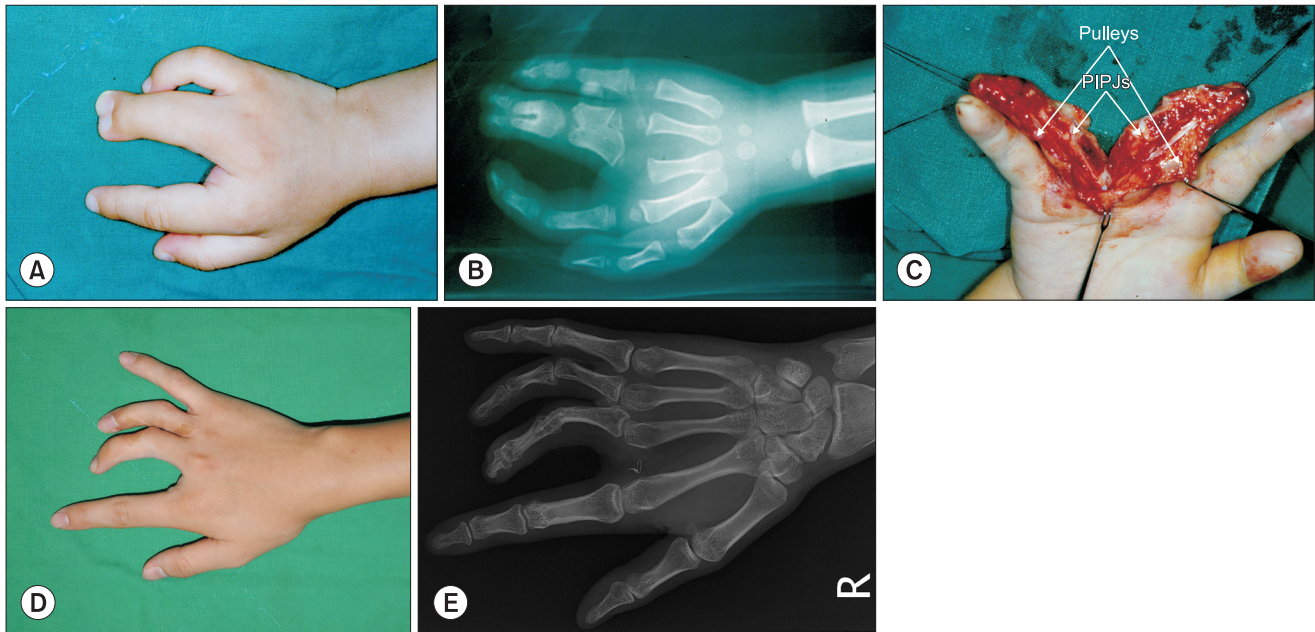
A complicated syndactyly of the right 3rd web of a case 19. (A) Preoperative dorsal view. (B) Preoperative X-ray finding. (C) Intraoperative view after division of fused proximal, middle phalangeal bones, and soft-tissue. Exposed proximal phalangeal joints covered with flaps, and pulleys restored with divided pulley of middle and ring fingers. (D) Postoperative dorsal view 22 years after surgery. (E) Postoperative X-ray finding of undergrowth and malrotation of middle and ring fingers. PIPJs: proximal interphalangeal joints.
